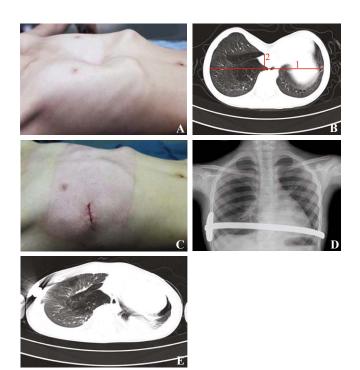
A 14-year-old female patient with pectus excavatum; B: CT scan of the chest of the patient. The chest Haller index is obtained by dividing measurement 1 by 2; C: Immediate postoperative appearance of the chest of the 14-year-old patient, with the small band-aid covering the right lateral chest wall incision. Chest radiography (D) and CT scan (E) of the chest of the same patient obtained after surgery.
